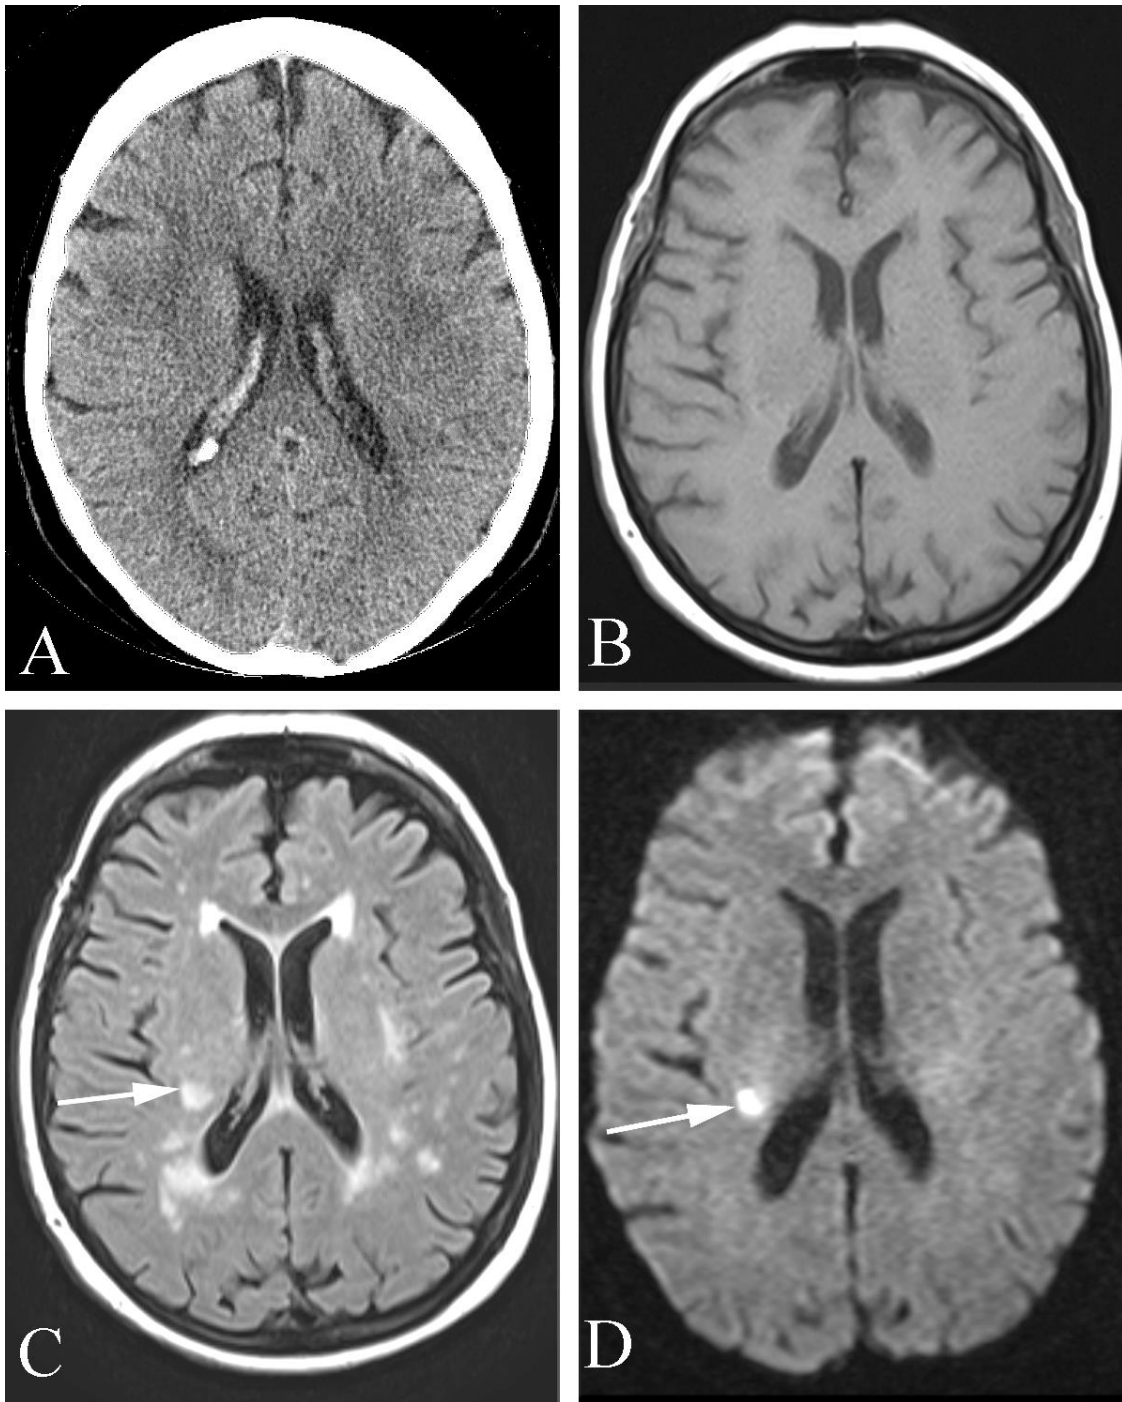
Stroke in an 85 year old woman with transient weakness six days prior to MR study. A. Axial unenhanced CT study shows no abnormality. B. Axial T1 MR weighted image also shows no abnormality. C. Axial FLAIR MR image demonstrates several focal areas of increased signal intensity, including one in the right cerebral hemisphere white matter (arrow). D. Axial diffusion weighted MR image demonstrates increased signal intensity indicating diffusion restriction (arrow) at the location of the lesion noted on image C., whereas the other white matter lesions seen on image C. show no diffusion restriction. These imaging findings indicate an acute infarction, and even though the patient's symptoms completely resolved she did not, by definition, have a TIA. The other areas of increased signal in C. likely represent chronic microvascular ischemic changes.
